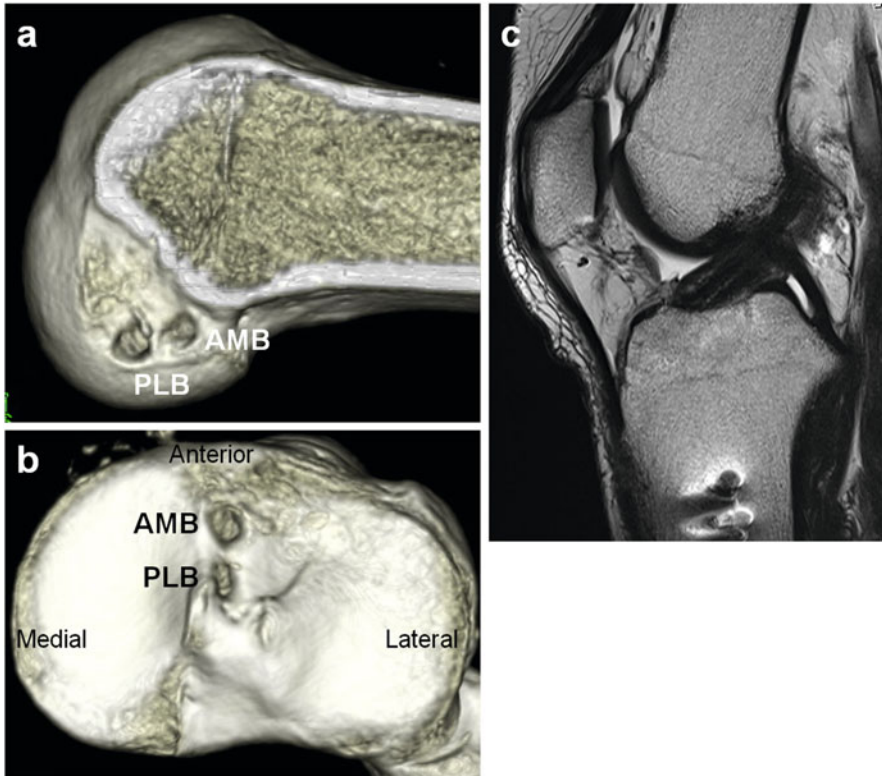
A representative case after anatomic double-bundle ACL reconstruction. (a, b) Femoral tunnel positions (a) and tibial tunnel positions (b) in three-dimensional computed tomography. (c) Magnetic resonance imaging (*sagittal view*). Both femoral and tibial tunnels were created within native ACL footprints
